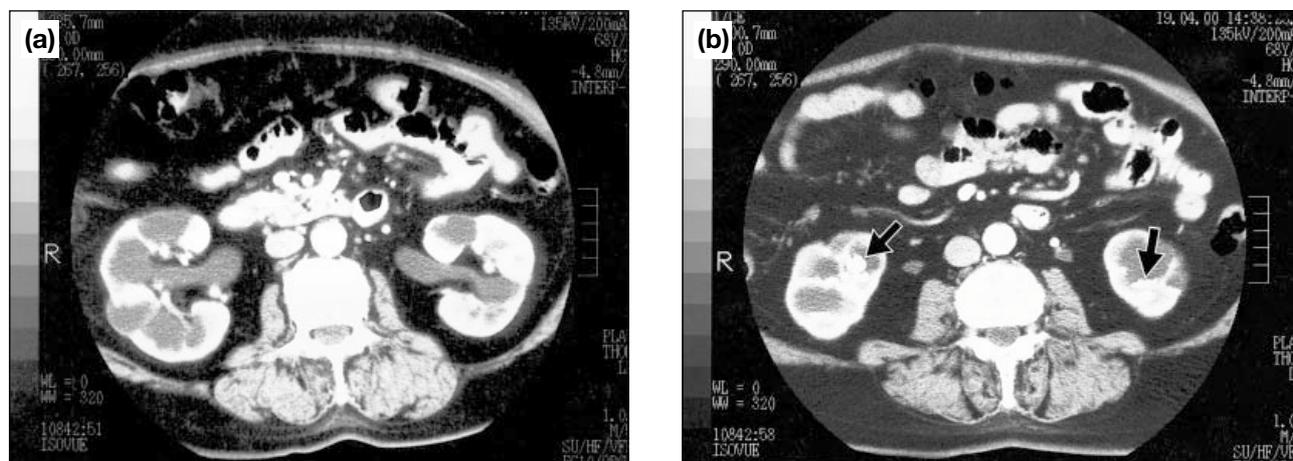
Intravenous contrast-enhanced abdominal CT at the level of the renal hilum demonstrates (a) dilatation of the calyces, parenchymal thinning, and normal renal pelvis and (b) calculi (arrows) in the lower pole calyces.
